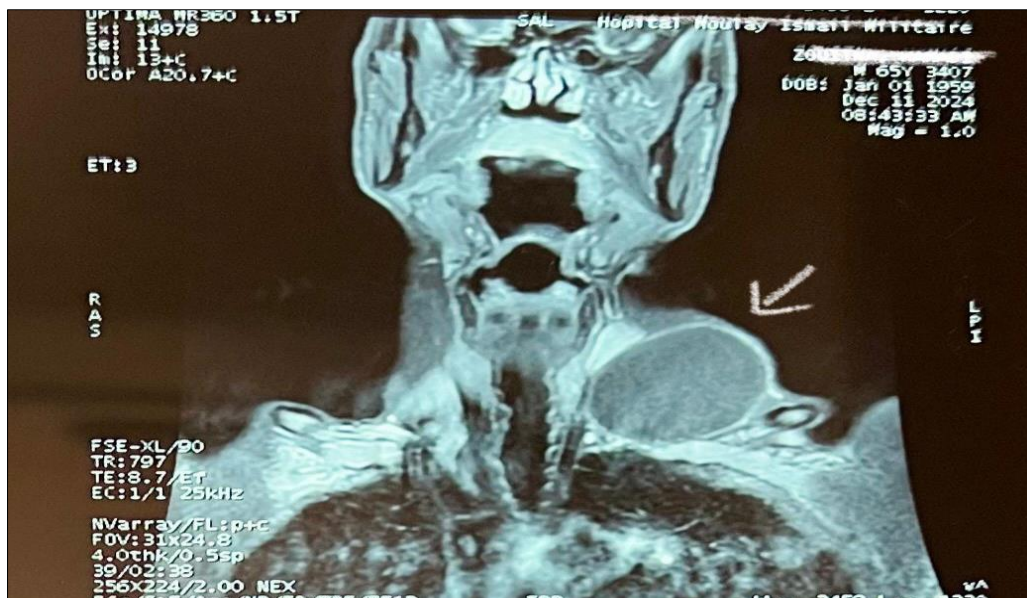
Coronal MRI view demonstrating a uniloculated cystic lesion located in the left subclavicular region
